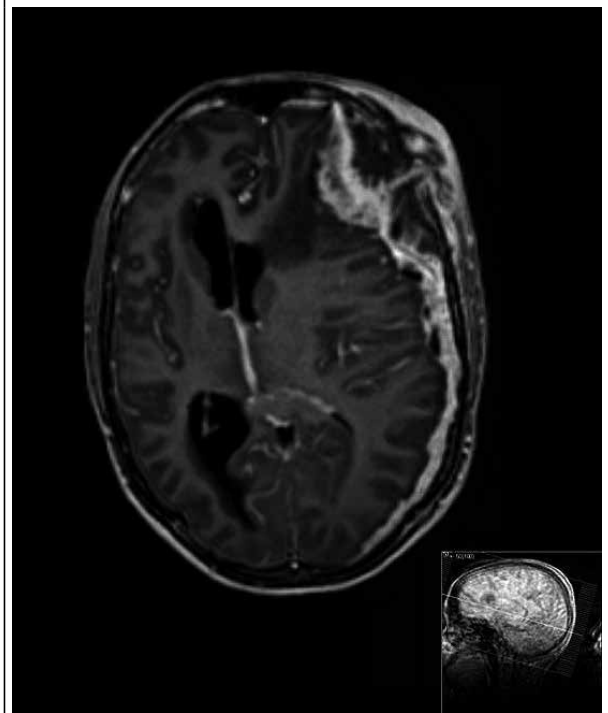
MRI scan (transversal plane) of the cerebrum showing a fluid collection in the subcutaneous tissue and a midline shift to the right caused by an epidural fluid collection and meningeal thickening on the left side.
